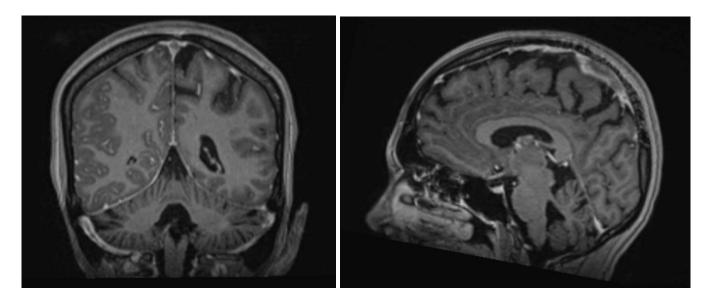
Contrast-enhanced T1 MPRAGE sequence MRI Brain in coronal (A) and sagittal (B) views showing filling defects in the superior sagittal sinus and right sigmoid sinus, consistent with thrombosis.
